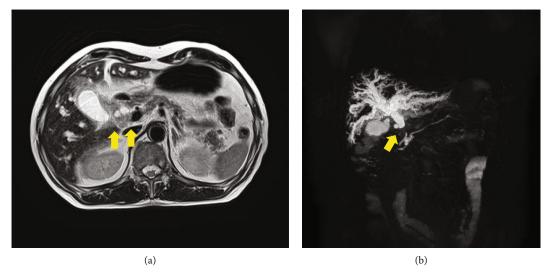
MRI and MRCP findings. (a) The tumor located in the distal bile duct had a low T2 signal (yellow arrow). (b) MRCP showed a filling defect of the distal bile duct and dilation of the hepatic-sided bile duct seen from the tumor (yellow arrow). MRCP: magnetic resonance cholangiopancreatography; MRI: magnetic resonance imaging.
